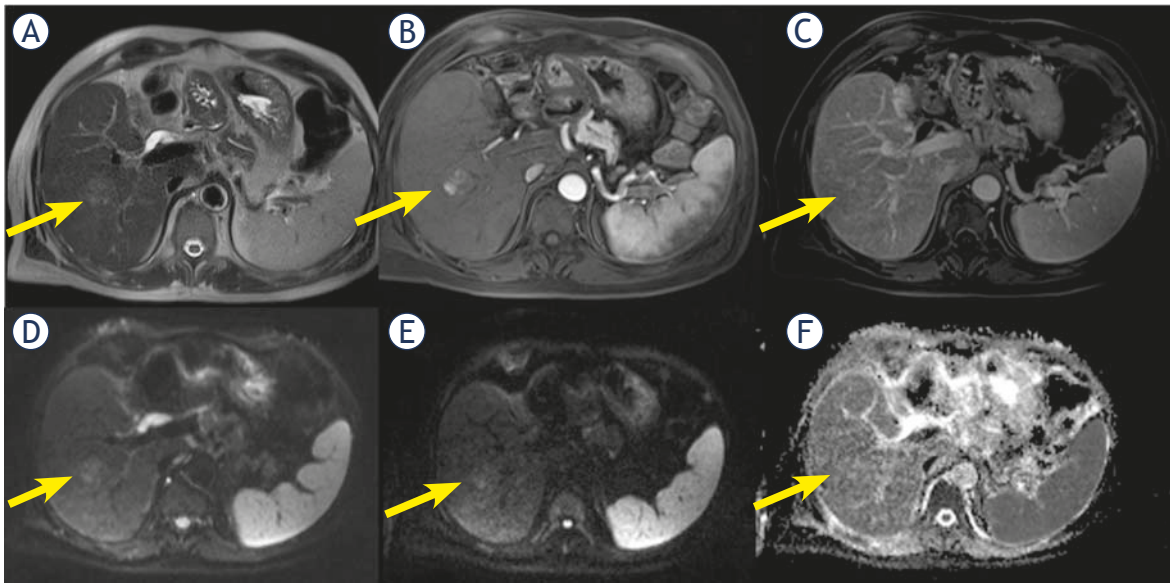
Man 56 y with combined hepatocellular-cholangiocarcinoma (cHCC-CCA) on VI hepatic segment. MRI study. The nodule is iso-hyperintense (arrow) in T2-W sequence (A), with inhomogeneous hypervascular appearance (arrow) during arterial phase of contrast study (B), without wash-out or capsule appearance (arrow) during portal phase of contrast study (C). The nodule shows restricted (arrow) diffusion (D, E and F) in diffusion weighted imaging (DWI) sequences.
